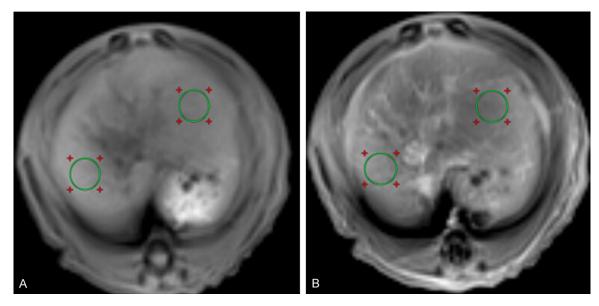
ROI of enhanced MR imaging. A is pre-enhanced phase T1WI; B is equilibrium phase imaging.
